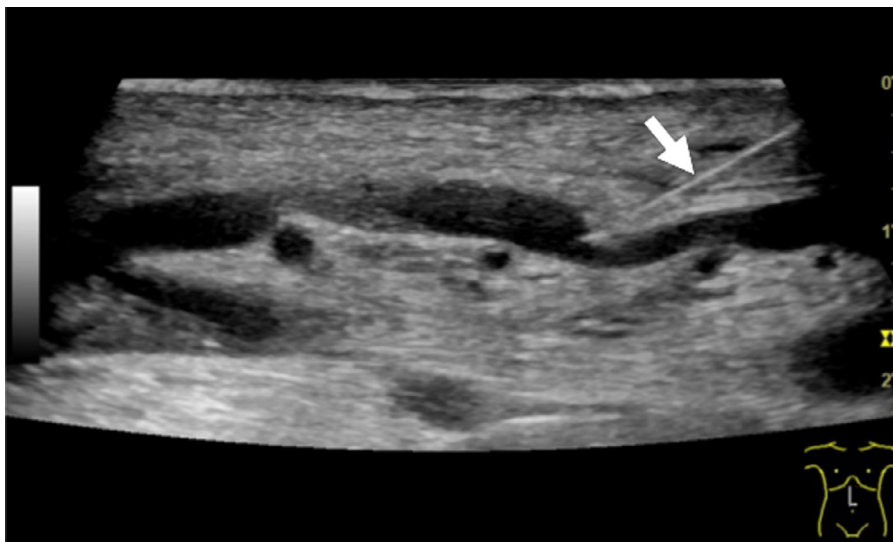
Direct percutaneous access to the middle colic vein. The ultrasound image reveals a 22-gauge needle (arrow) that hits the anterior wall of the middle colic vein
